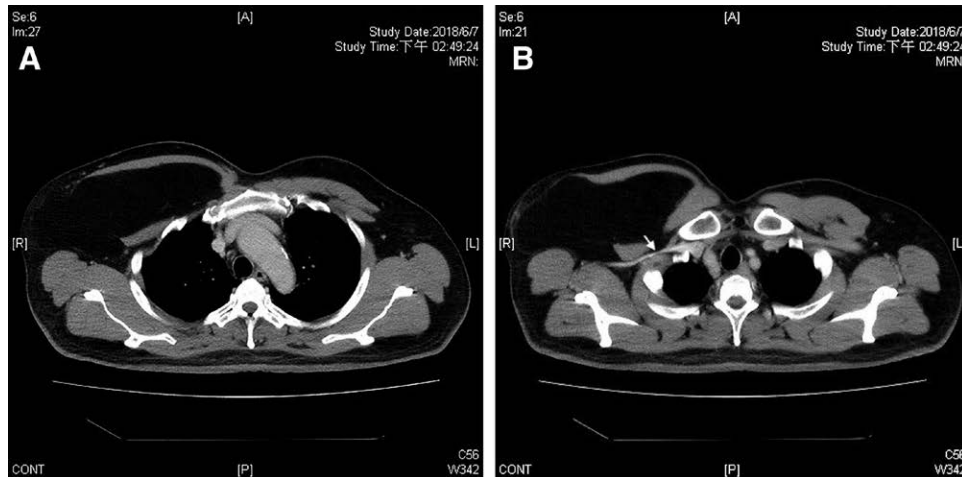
CT images. A, CT image of the giant interpectoral lipoma in axial view. B, CT image of the patient revealing compression of the subclavian vein by the giant interpectoral lipoma.
